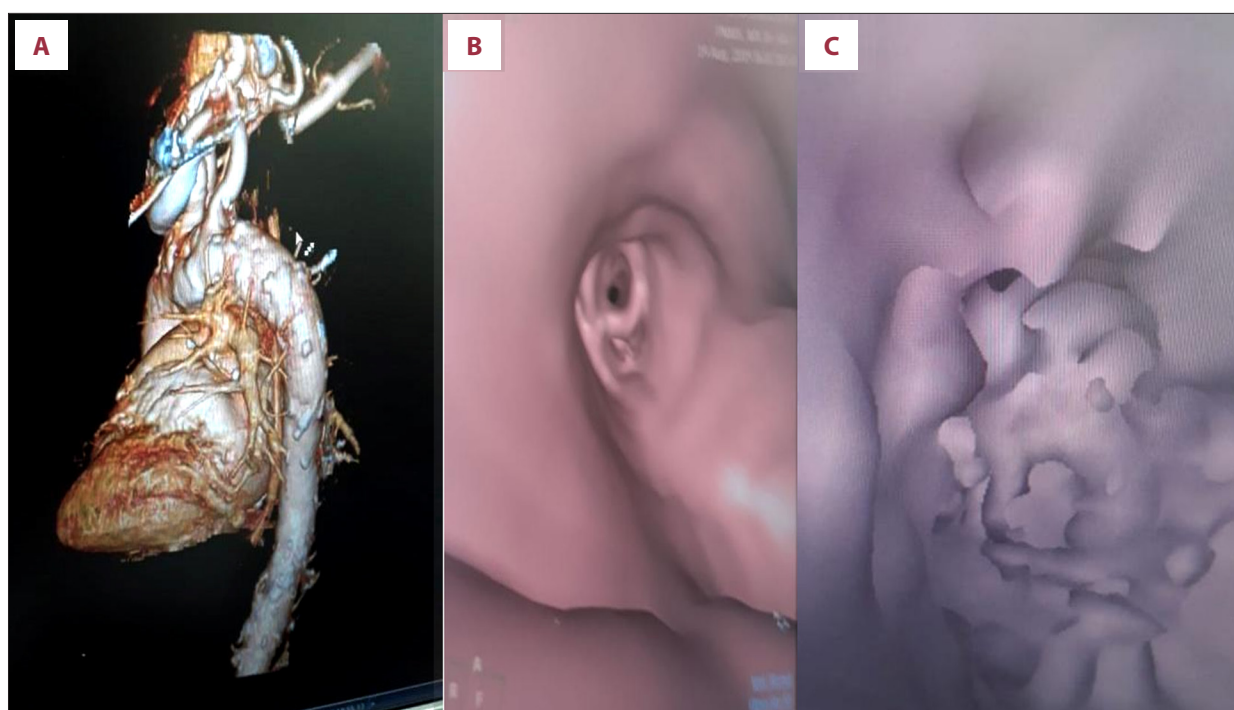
(A) Computed tomography angiography with venous and arterial phase and three-dimensional reconstruction: azygos vein aneurysm is observed. Virtual tomographic image of bronchoscopy (B, C).
